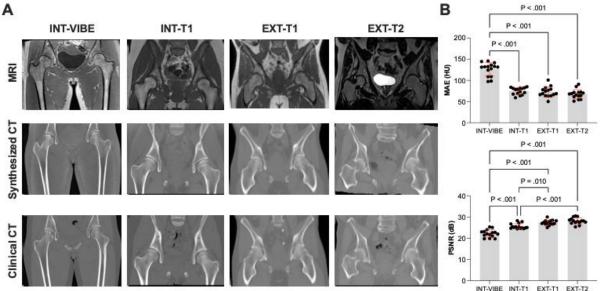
(A) Synthetic CT from multiple clinical MR sequences compared to original CT scans. (B) Performance metrics (MAE and PSNR) computed between synthetic CT volumes and corresponding original CT volumes.
